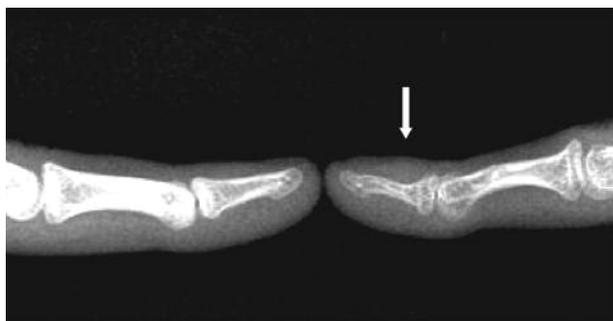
This patient had a vascular anomaly of the right hand and showed typical clinical symptoms of a glomus tumour. Radiographs show a small distal phalanx on the right side and a soft tissue enlargement (see arrow).
